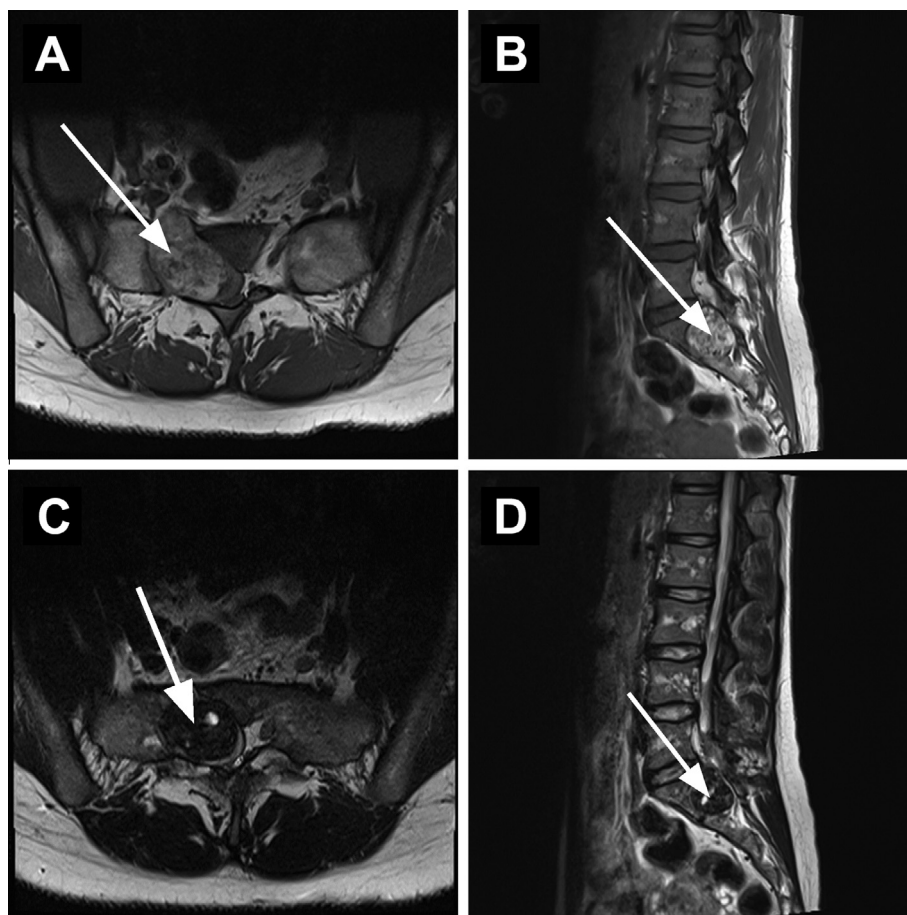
MRI of lumbar spine (A) Axial T1-weighted, (B) Sagittal T1-weighted, (C) Axial T2-weighted, (D) Sagittal T2-weighted. The mass occupies the L5-S1 vertebrae. Arrows indicate position of the mass at the S1 neural foramen.
